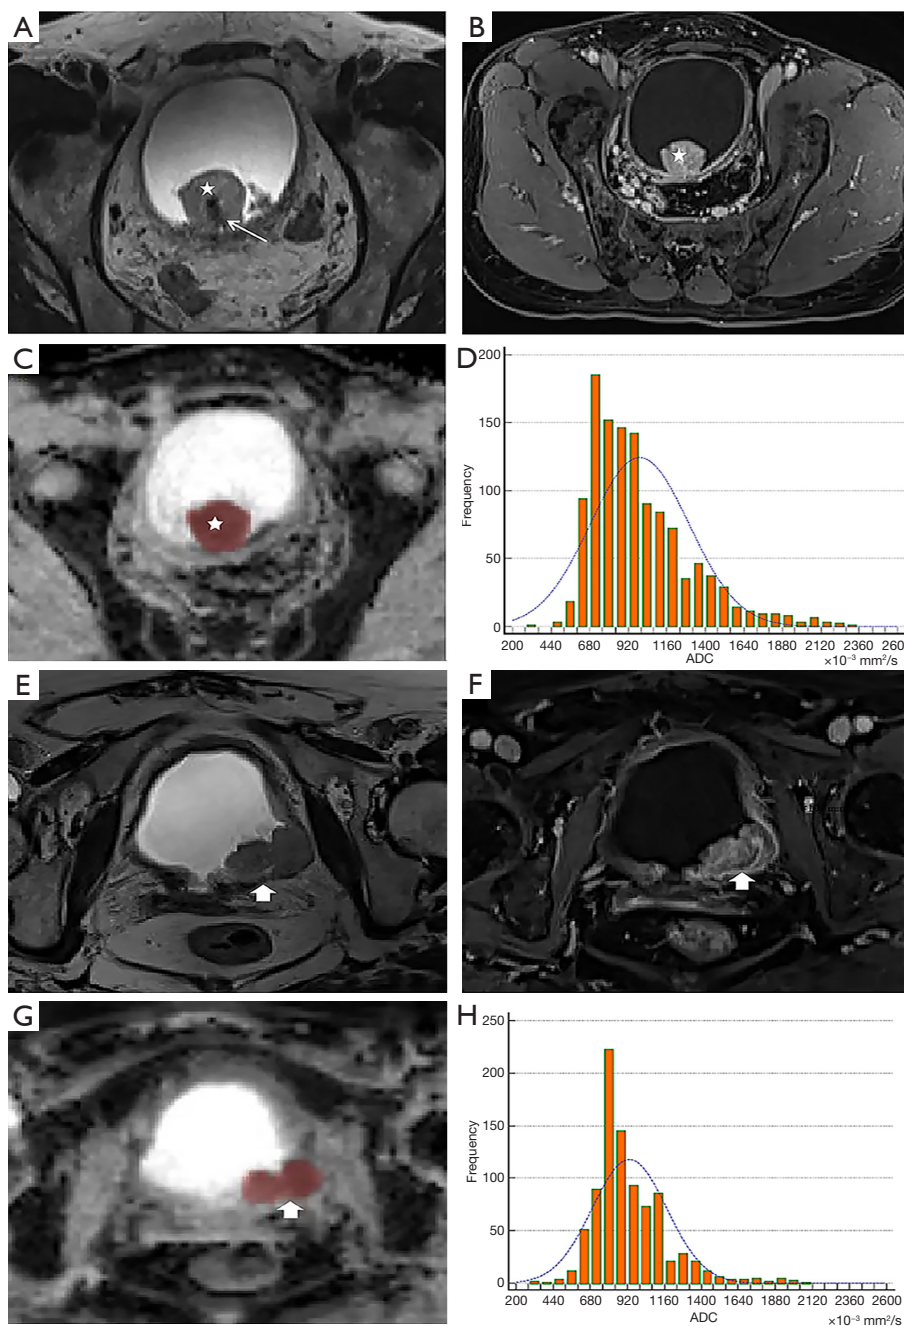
A 57-year-old man with T1 stage papillary urothelial carcinoma in the posterior bladder wall. The lesion (white star) had an intermediate signal on T2WI (A), was obviously enhanced in the DCE image (B) and had a low signal in the ADC map (C), and the stalk (thin white arrow) of the lesion had a low signal and was seen clearly on T2WI (A). The line signal of the bladder wall adjacent to the lesion was consecutive. The ADC histogram of the corresponding lesion is shown in (D). A 70-year-old woman with T2 stage papillary urothelial carcinoma in the left posterior bladder wall. The lesion (thick white arrow) had an intermediate signal on T2WI (E), was obviously enhanced in the DCE image (F) and had a low signal in the ADC map (G). The line signal of the bladder wall adjacent to the lesion was interrupted. The ADC histogram of the corresponding lesion was shown in (H). T2WI, T2-weighted imaging; DCE, dynamic contrast-enhanced; ADC, apparent diffusion coefficient.
